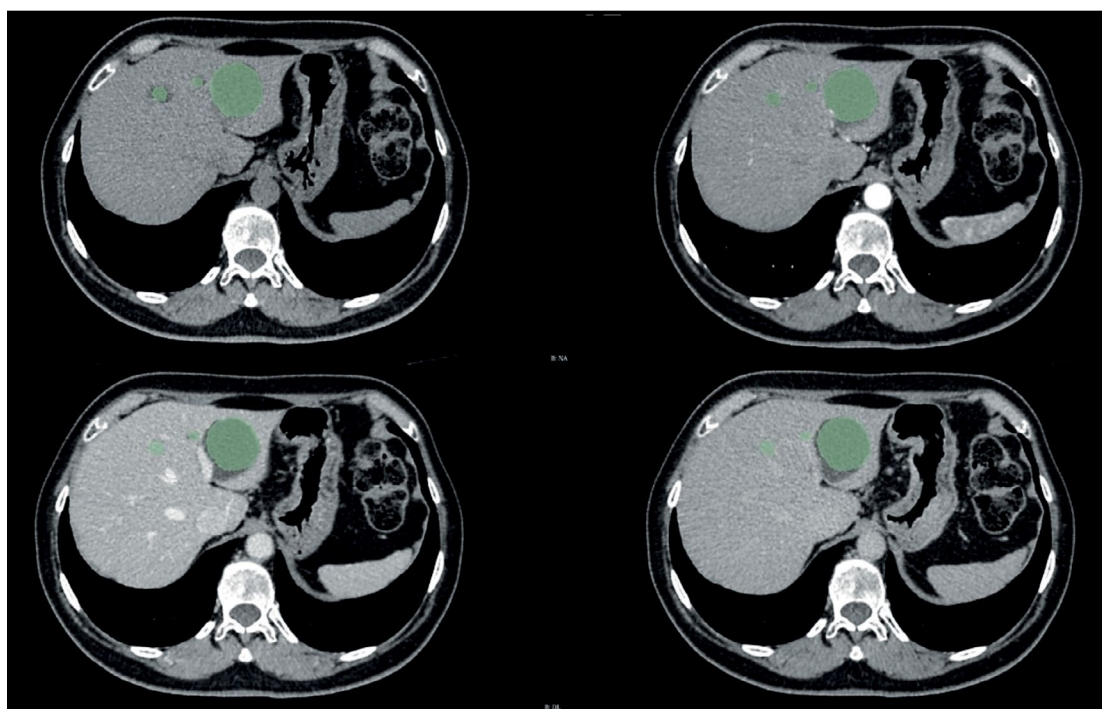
An example of liver neoplasm segmentation by an algorithm based on a contrast-enhanced CT scan.
